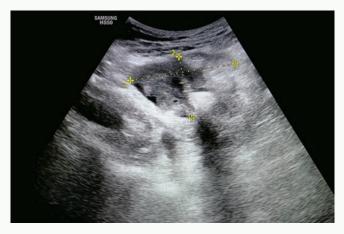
This is another longitudinal view of the lesion. The lesion is negative for Doppler signal.
